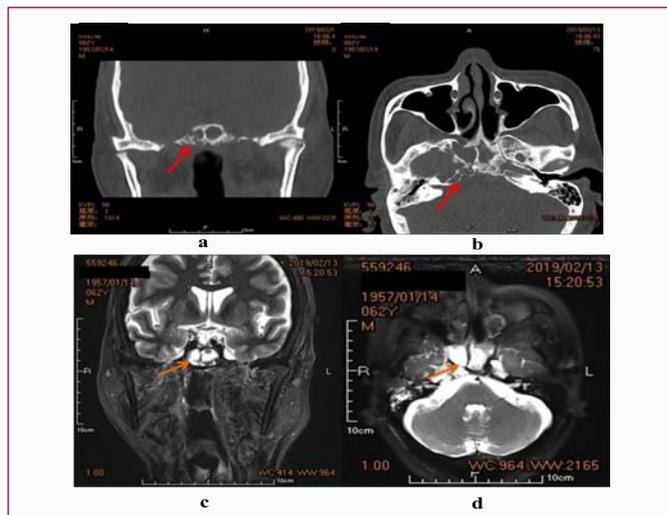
The coronal and horizontal position CT and MRI scan of the patient in the second time of CSF rhinorrhea in 2019. a,b) CT scan showed in the bottom of the right side sphenoid sinus, bone were ethmoid-like defect (Red arrow). c,d) MRI showed T2WI high signal connect the intradural and the sphenoid (Orange arrow).
